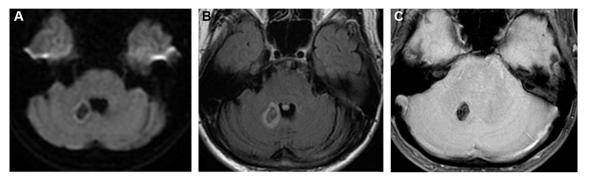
Sixty-five-year-old man presenting with cerebellar syndrome and hypotonia of the 4 limbs lasting less than 2 hours. 1.5-Tesla MRI performed 4 hours after the onset of symptoms demonstrating right cerebellar hematoma, hypointense with a hyperintense rim on DWI (A) and FLAIR (B), with marked hypointensity on T2*-weighted sequence (C).
